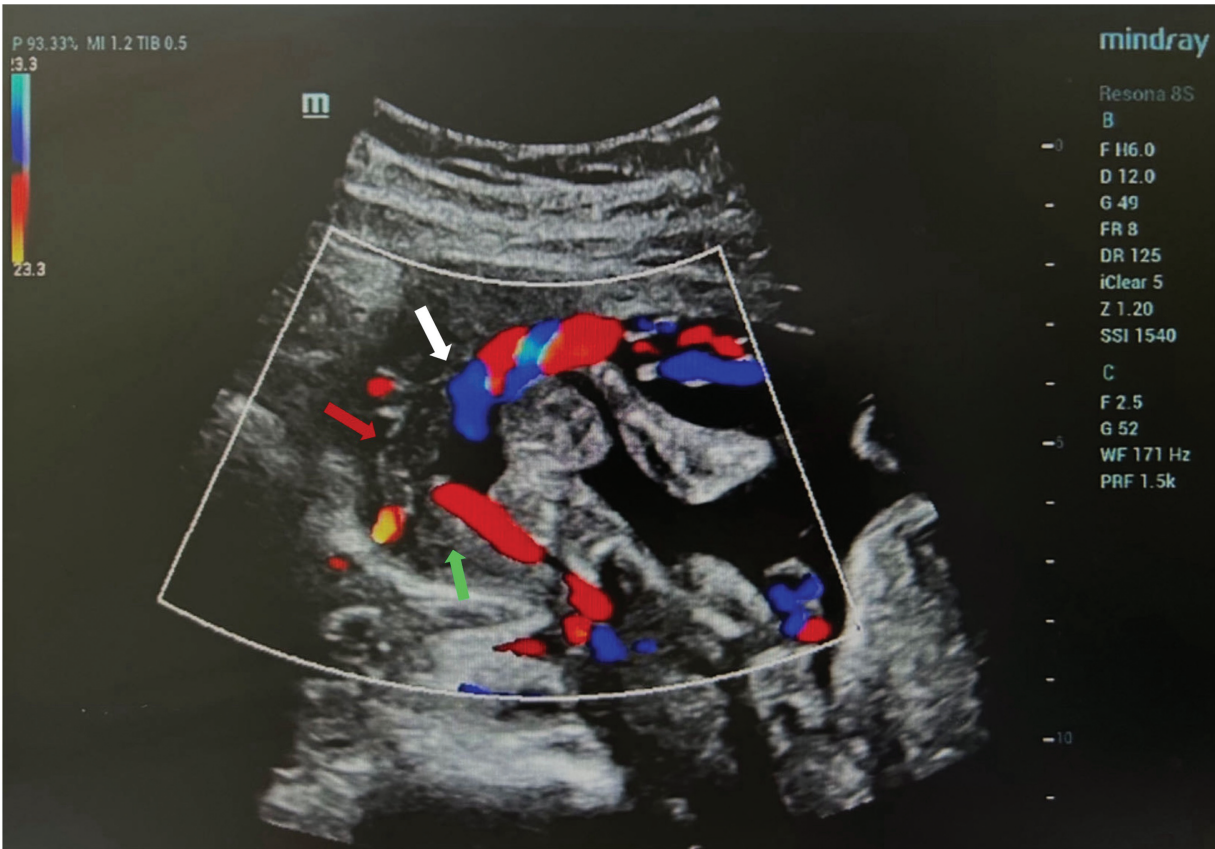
Ultrasound image of velamentous cord insertion in Case 9. Second-trimester ultrasound image of Case 9 reveals velamentous cord insertion. The white arrow points to the location of the umbilical cord insertion, while the red arrow indicates the amniotic membrane and the green arrow denotes the placenta.
